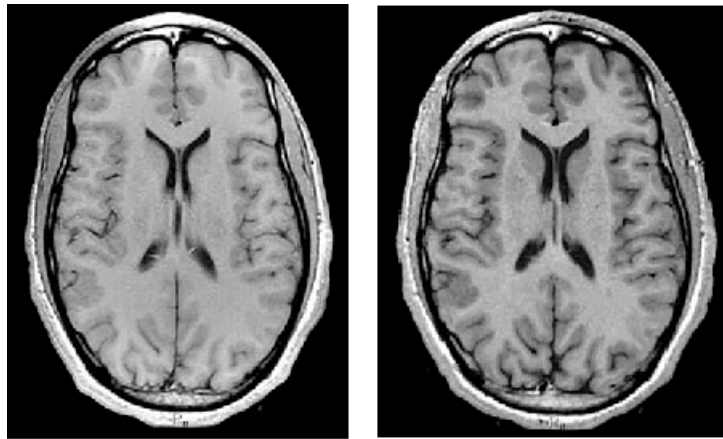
Axial representation of an MRI with Longitudinal relaxation time (T1) [5]
